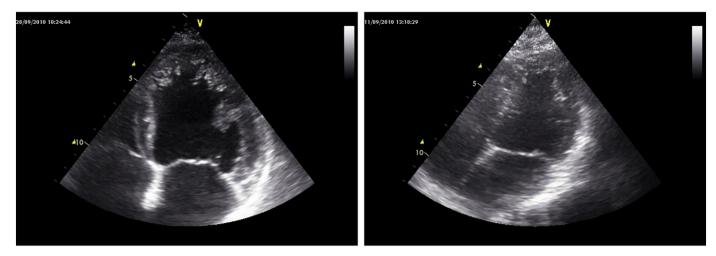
Left: Echocardiographic apical four-chamber view showing left ventricular hypertrabeculation/noncompaction affecting the apical and lateral region of the left ventricle. The left ventricle is dilated and has a reduced systolic function. Right: Echocardiographic apical four-chamber view of the daughter of the patient on the left, showing left ventricular hypertrabeculation/noncompaction affecting the apical region of the left ventricle. The left ventricle is not dilated and shows a normal systolic function.
